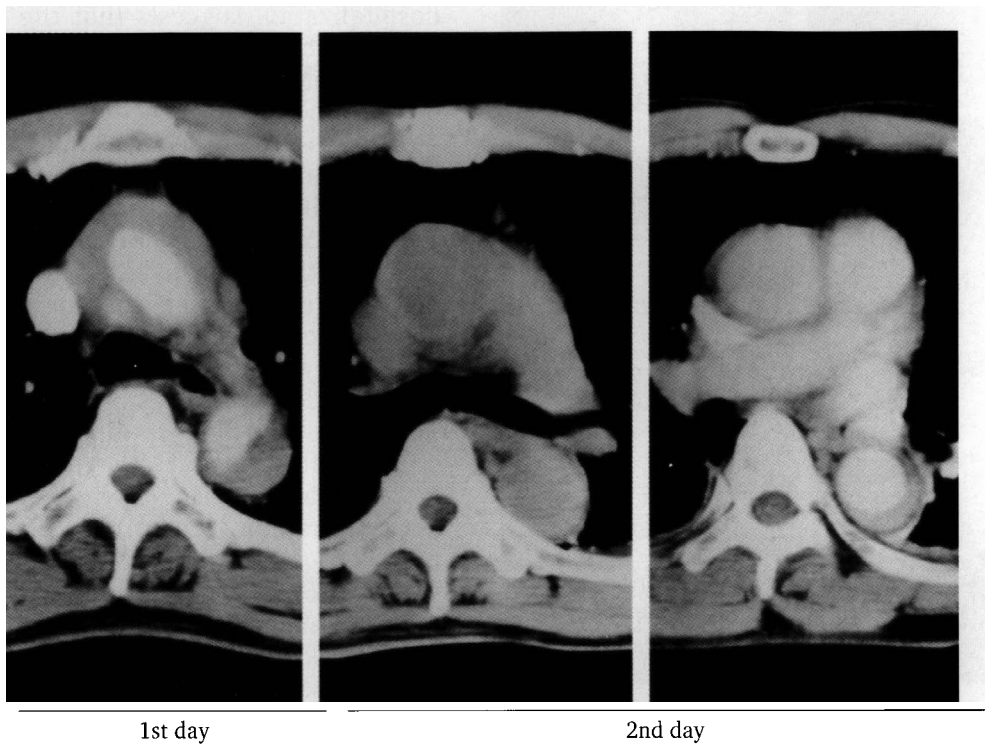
Computed tomography (CT) in a patient with chest and back pain. Left, emergency contrast CT obtained on admission, showing narrowing of the true lumen and formation of a false lumen in the ascending and descending aorta. A diagnosis of Stanford type A aortic dissection with a false lumen was made. Middle and right, noncontrast CT obtained on the second day of hospitalization showing increased brightness of the aortic wall and resolution of the false lumen in the ascending aorta.
